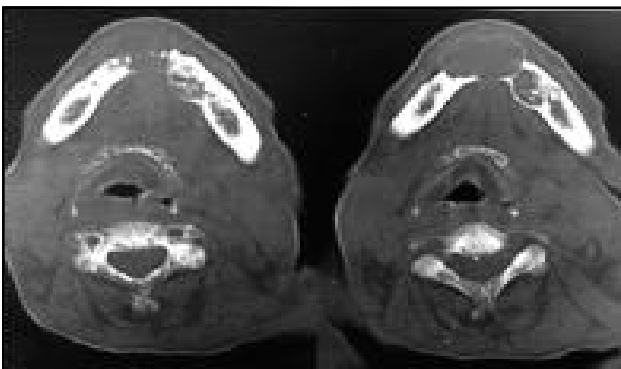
Computed tomography scan of the mandible; osteolytic area with irregular margins in the midline of mandible.
